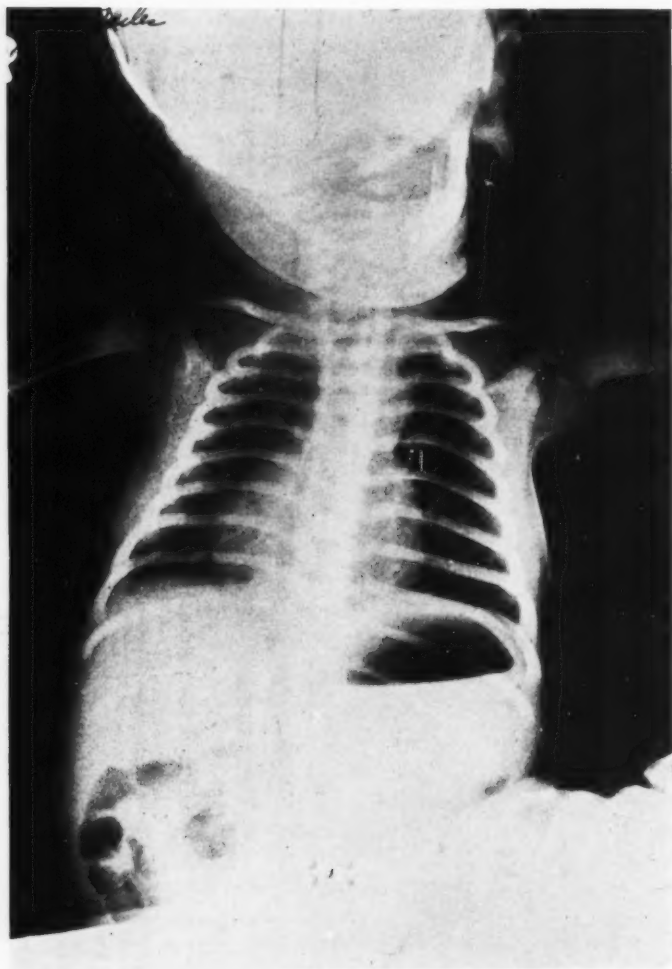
R. M. X-ray of the chest taken after a single irradiation of 75 r to the mediastinum revealing mirror image dextrocardia. Note the stomach bubble to be on the left.
